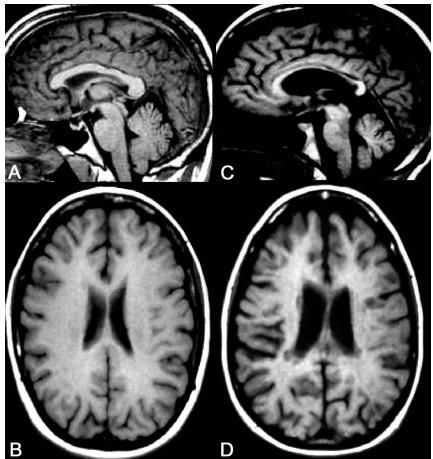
Brain atrophy in multiple sclerosis shown on MRI scans. Non-contrast T1-weighted images are shown of normal controls in the fifth decade (a-b) compared with age-matched patients with MS (c-d). Note thinning and decreased volume of corpus callosum and posterior fossa structures in MS (c). Note prominence of cortical sulci (suggesting cortical atrophy) and ventriculomegaly (indicating central atrophy) in MS (d). Using this type of visual analysis, ordinal rating systems can semiquantitatively measure atrophy (113).
